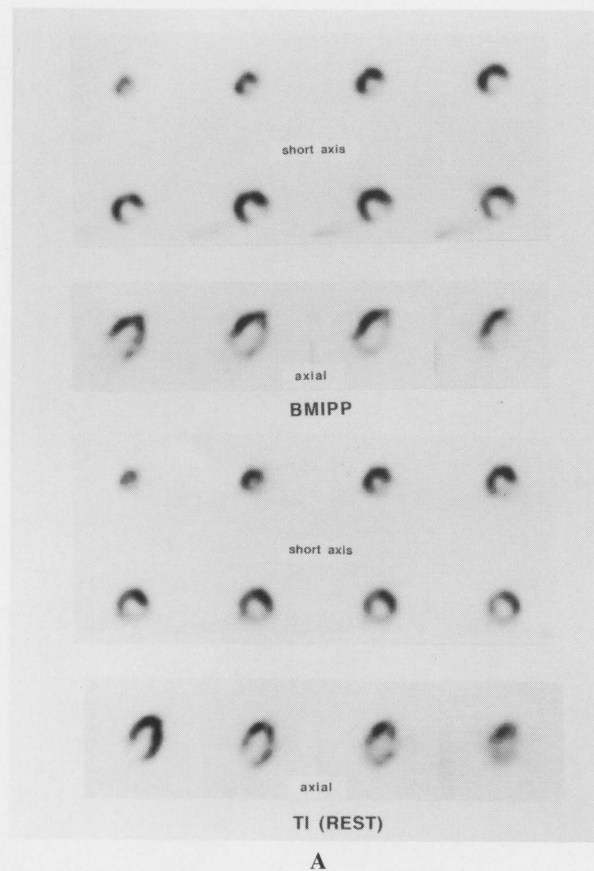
A) 62-year-old man with lateral MI after 4 weeks from onset. Coronary arteriogram revealed 90% stenosis of LCX #11. Wall motion was almost normal in left ventriculogram. A series of short-axis and axial slices of BMIPP images (Top) and Tl images (Bottom). BMIPP uptake is less than Tl uptake in the lateral region. B) A series of short-axis and axial slices of stress Tl images (Top) and delayed Tl images (Bottom) from the same patient. No redistribution is observed in lateral wall. C) A series of axial (Top) and horizontal long-axis (Bottom) slices of FDG PET images from the same patient. FDG uptake is observed in the lateral wall.
